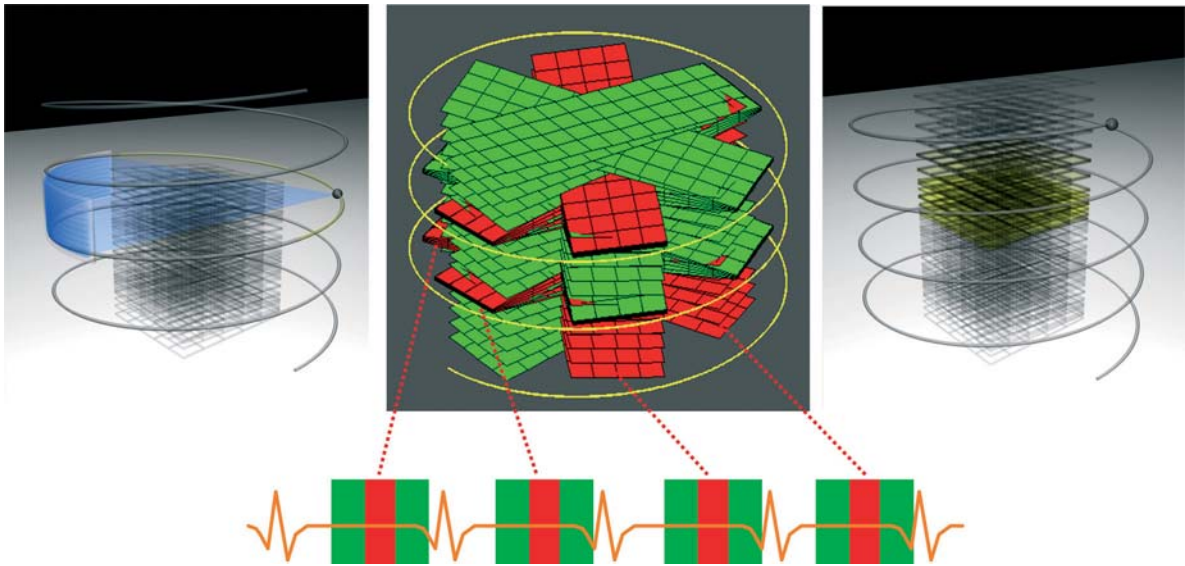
The principle of cardiac cone-beam reconstruction with generation of individual double-oblique image stacks (so-called booklets) in each heart cycle that are subsequently reformatted to overlapping transaxial image slices
